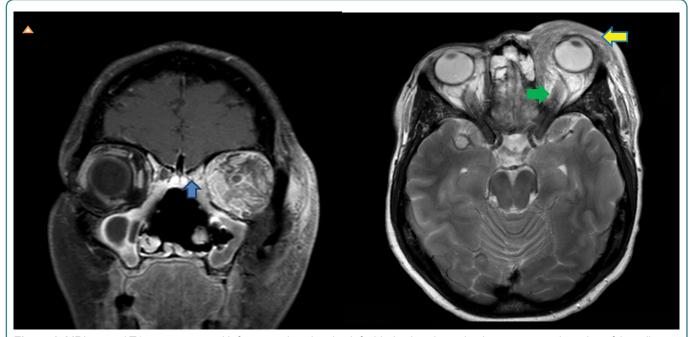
MRI coronal T1 post contrast with fat saturation showing left sided subperiosteal enhancement and erosion of the adjacent ethmoid air cells [blue arrow]. Axial enhanced fat suppressed T2 MRI showing preseptal [yellow arrow] and postseptal enhancing tissue with lateral displacement of globe [green arrow].
